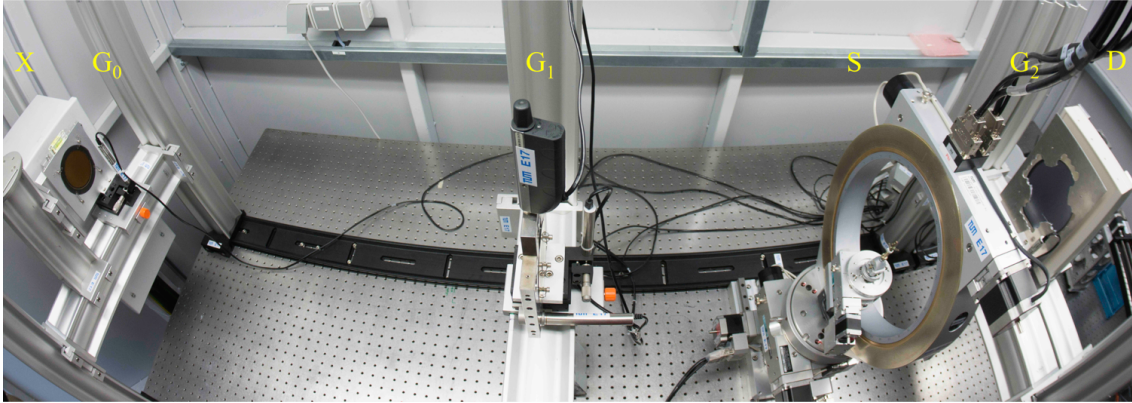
Photography of the XTT setup used to measure the samples. From left to right: (S) x-ray source, (G_0) source grating, (G_1) phase grating, (S) sample mounted on the Euler cradle, (G_2) the analyzer grating and, (D) the detector
